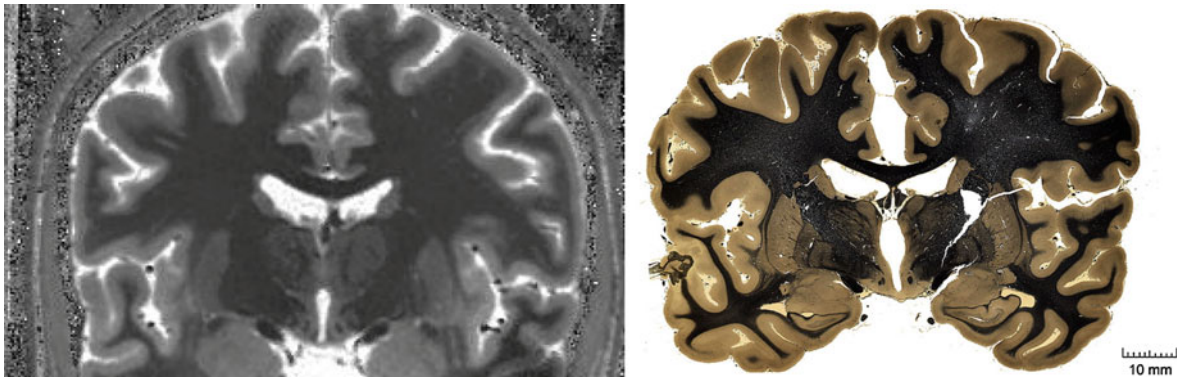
Comparison between a T_1 map (left) obtained at 7 T in vivo using inversion recovery MP-RAGE MRI (0.5-mm isotropic resolution, nine inversion times) and a similar section
